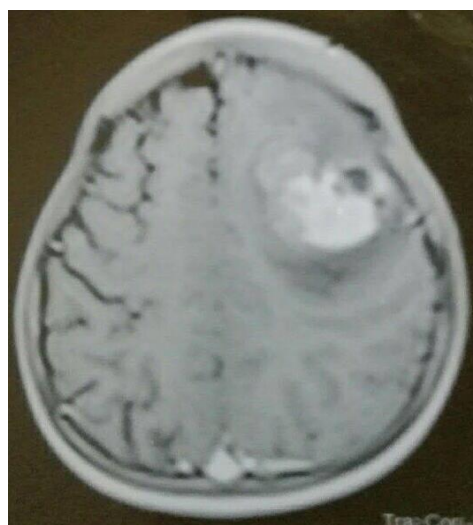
Axial T1 post-contrast MRI image in a 7 years female patient shows left-sided parietal abscess.
